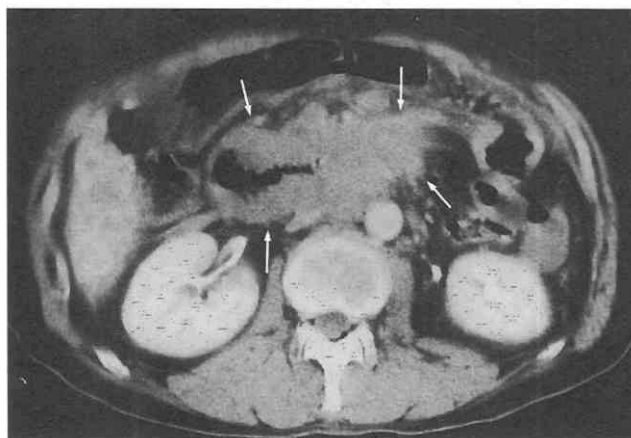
Duodenal lymphoma. CT scan shows irregular concentric bowel wall thickening (*arrows*) in the duodenum. Note lymphadenopathy along the root of mesentery and lymphomatous nodules in the liver.
